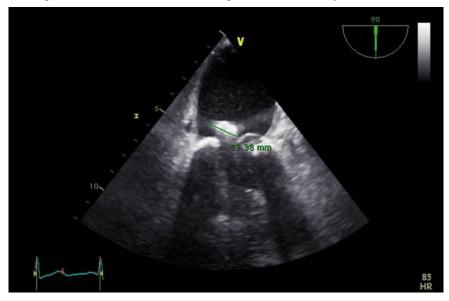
Transesophageal echo (mid esophageal 2 chamber view) at 35 cm from incisors showing anterior mitral leaflet (A1, A2, A3) and posterior mitral leaflet (P3), with an oval pediculated mass of 17.38 mm length, with protrusion between mitral leaflets
